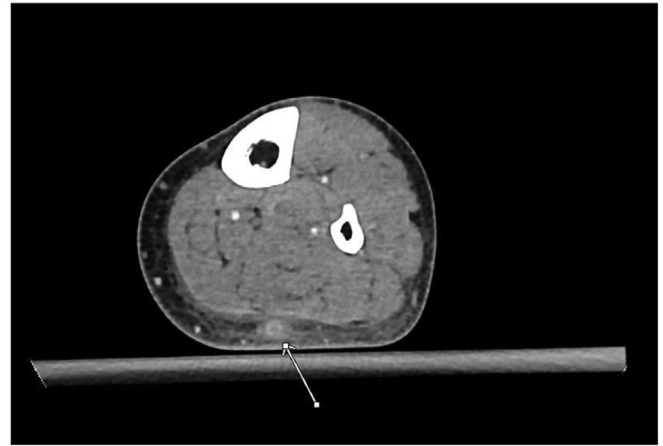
Computed tomography (CT) scan with intravenous contrast of the left lower extremity. *Arrowhead* indicates expansion of the lesser saphenous vein with adjacent edema and fat stranding, suggestive of superficial thrombophlebitis with surrounding cellulitis and edema.
